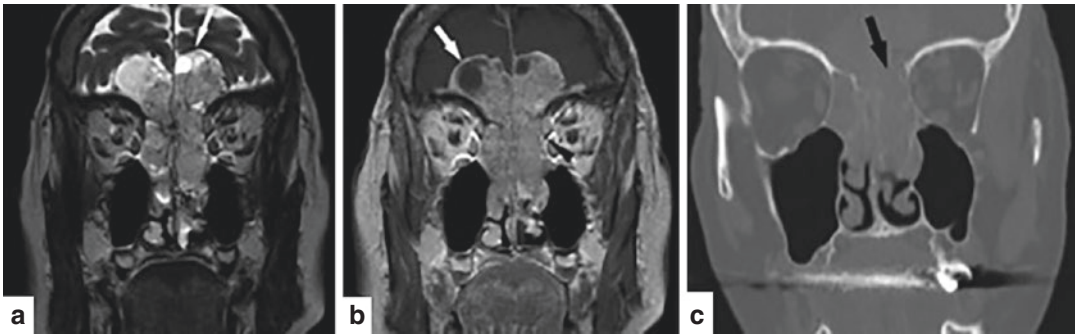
Esthesioneuroblastoma. A 70-year-old female who presented with nasal congestion. (a) Coronal T2-weighted MR image shows a bulky lobulated mass of intermediate T2 signal in bilateral nasal cavities with intracranial extension. Note the cysts at the leading edge of the intracranial component (arrow), a characteristic feature of esthesioneuroblastoma when extending intracranially. (b) Coronal contrast-enhanced T1-weighted MR
